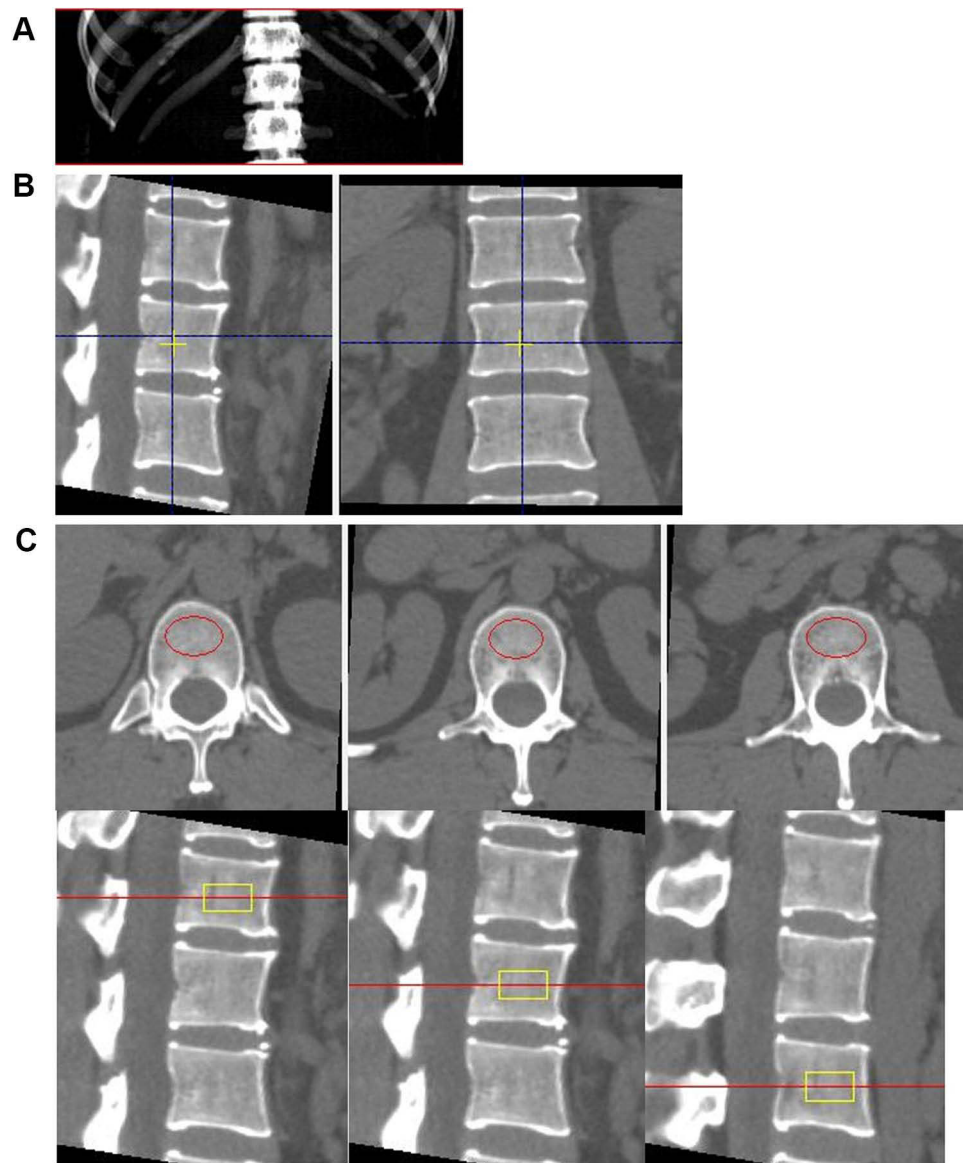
Measurement of the bone mineral density of T12, L1 and L2 with Mindways quantitative computed tomography pro system. (A) Volume rendering view of a quantitative computed tomography scan. (B) Positioning of the sagittal and axial views for subsequent automatic placement of region of interest (ROIs). (C) ROIs shown as red ellipse in axial view and yellow rectangle in sagittal view.
